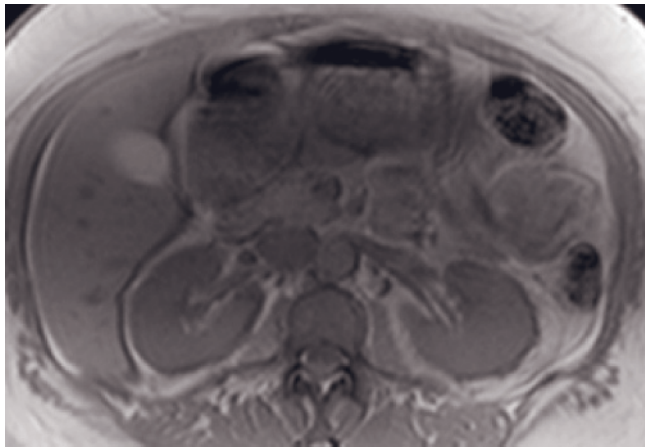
Renal metastases, undifferentiated adenocarcinoma. T1-weighted immediate (*a*) and 90-s (*b*) postgadolinium SGE and interstitial-phase fat-suppressed gadolinium-enhanced SE (*c*) images. Massive retroperitoneal adenopathy with extension through the renal hilum and invasion of the renal medulla is present (*a-c*). Extensive infiltration of the medulla with relative sparing of the cortex is well shown on interstitial-phase images (*b, c*). This appearance of renal involvement resembles lymphoma. Thickening of Gerota fascia (arrow, *c*) and retroperitoneal adenopathy are best shown on the gadolinium-enhanced fat-suppressed image, reflecting good conspicuity of enhanced malignant tissue in a background of suppressed fat.
